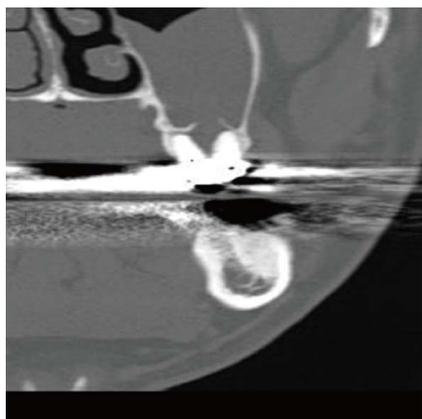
Coronal view of the maxillary molar with multi-detector computed tomography. The absence of cortication between the root apex and maxillary sinus can be observed.
